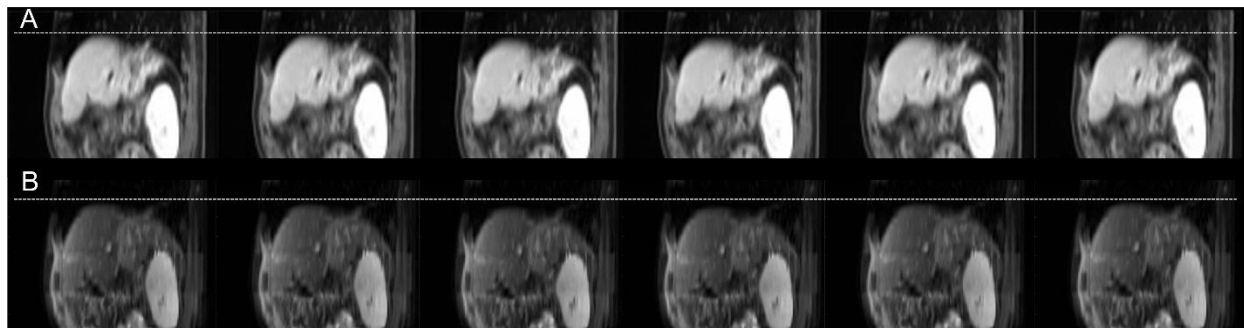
An example of 4D-MRI in a patient with liver cancer. A shows the T₁w 4D-MRI image. B shows the T₂w 4D-MRI image. The white dashed line helps to better visualize motion.
